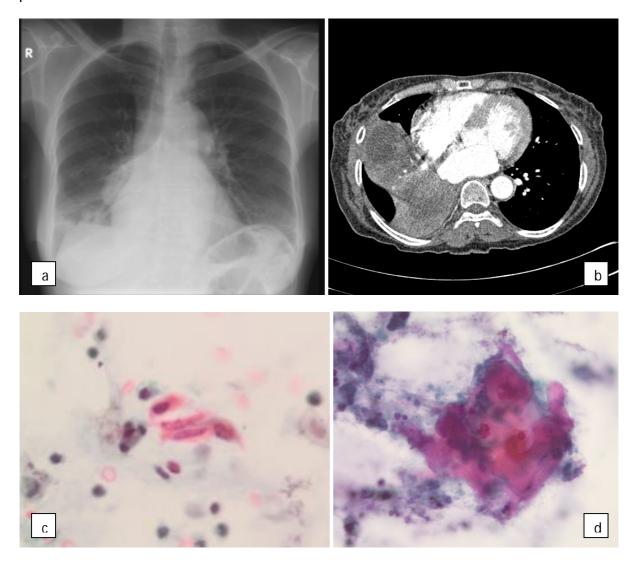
Mass in right lower lobe, occlusion of the bronchus and a mass-nodal-complex on the right on chest X-ray (a) and CT (b). Sputum - suspicious for malignancy. Sparse spindled cells present with elongated nuclei and dense cytoplasm (c). TTNA - Non-small cell carcinoma, squamous cell carcinoma with necrosis (d).
